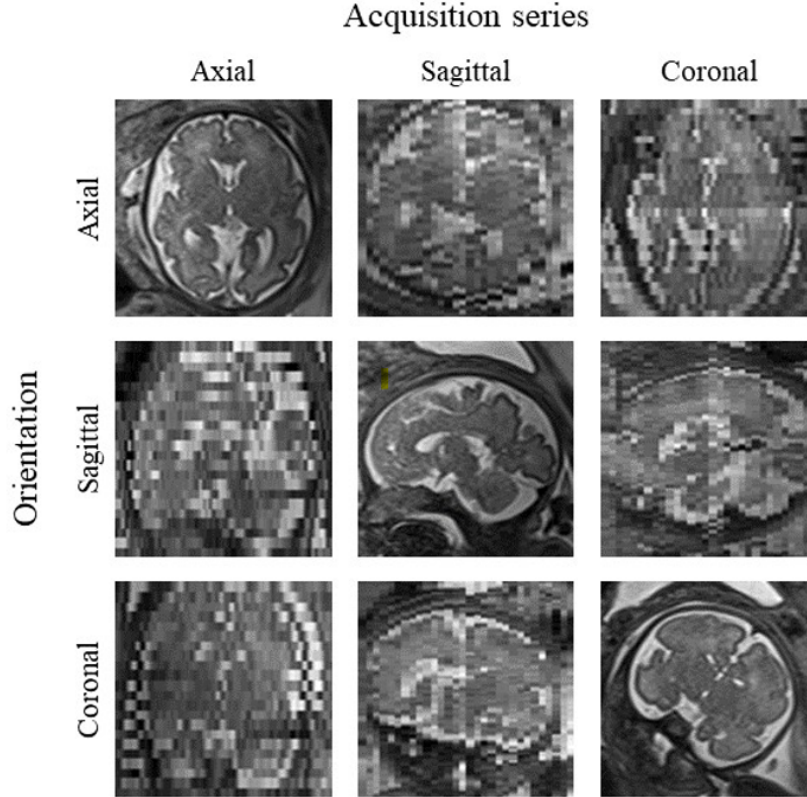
Example of a fetal brain MRI, showing three orthogonal acquisition series of the same subject (30 weeks gestational age), made using the HASTE sequence.
